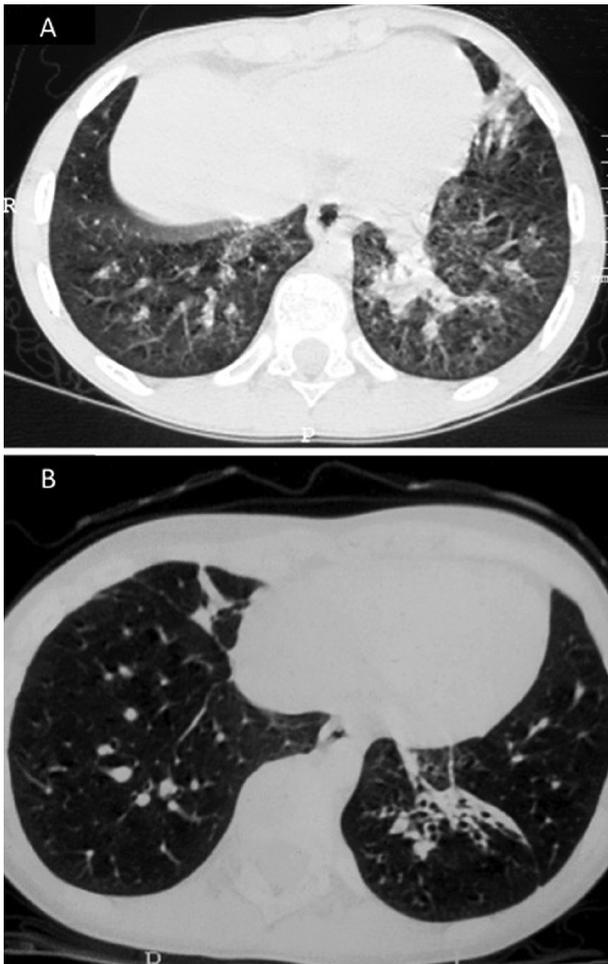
Chest high-resolution computed tomography from two children with esophageal atresia and tracheoesophageal fistula repaired at birth and followed at our department: (A) left lower lobe consolidations and (B) left lower lobe consolidation with bronchiectasis.
